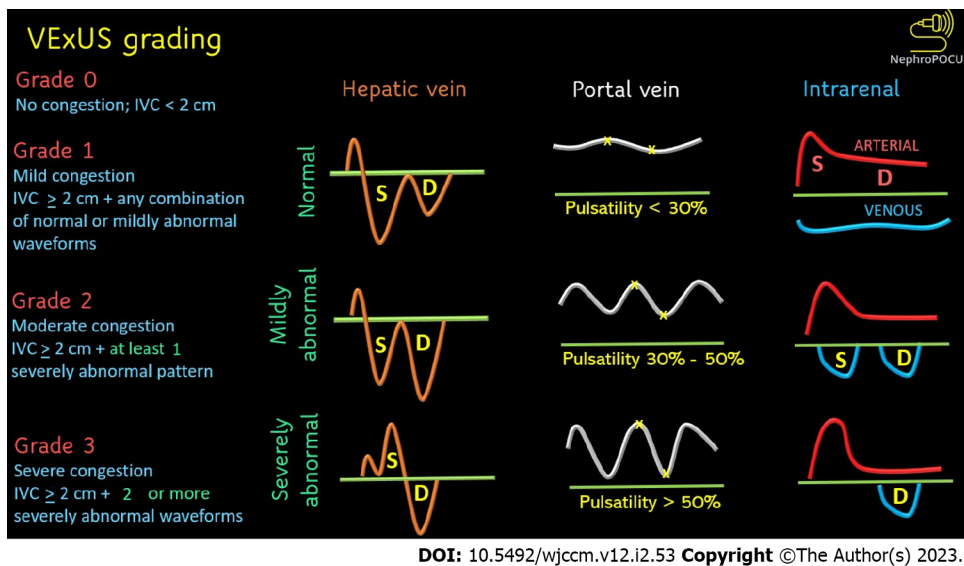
Venous excess ultrasound grading. When the diameter of the inferior vena cava is > 2 cm, three grades of congestion are defined based on the severity of abnormalities on hepatic, portal, and renal parenchymal venous Doppler. Hepatic vein Doppler is considered mildly abnormal when the systolic (S) wave is smaller than the diastolic (D) wave, but still below the baseline; it is considered severely abnormal when the S-wave is reversed. Portal vein Doppler is considered mildly abnormal when the pulsatility is 30% to 50%, and severely abnormal when it is ≥ 50%. Asterisks represent points of pulsatility measurement. Renal parenchymal vein Doppler is mildly abnormal when it is pulsatile with distinct S and D components, and severely abnormal when it is monophasic with D-only pattern. Figure adapted from NephroPOCUS.com with permission.
